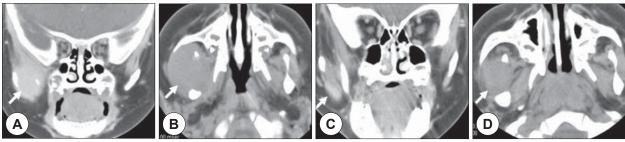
A and B: Temporal bone CT shows a 4×4 cm sized mass shadow in right pterygopalatine fossa destructing mandible bone (arrow)(A: Coronal view, B: Axial view). C and D: Temporal bone CT shows decreased mass $size(2 \times 2cm)$ after interferon alpha therapy(arrow)(A: Coronal view, B: Axial view).
